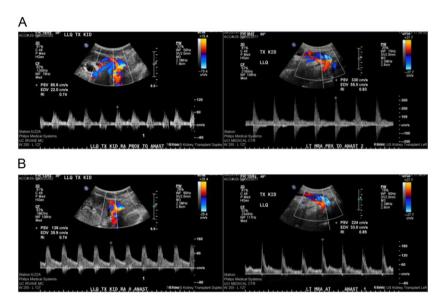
Comparison of duplex ultrasound of transplanted kidney in August 2015 compared to September 2015. Elevated velocities proximal and at the main renal artery anastomosis to 330 cm/s from 85.6 cm proximal to anastomosis (A) and 224 cm/s from 139 cm/s at the site of the anastomosis (B).
